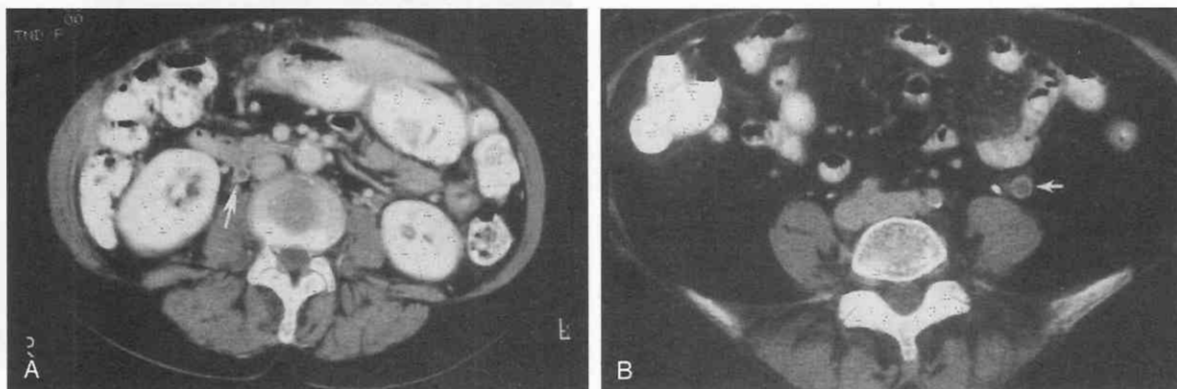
Gonadal vein thrombosis. *A*, Enhanced CT scan shows a low-attenuation clot in the right gonadal vein (arrow) of a patient with breast carcinoma. She had been receiving high-dose chemotherapy. *B*, On this enhanced CT scan from another patient with cancer, the thrombus is easily visualized in the left gonadal vein (arrow).
